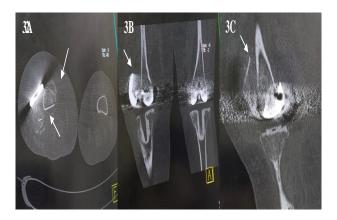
(A-C): Axial CT scans showing type 3 femoral component fracture of medial condyle [R].
